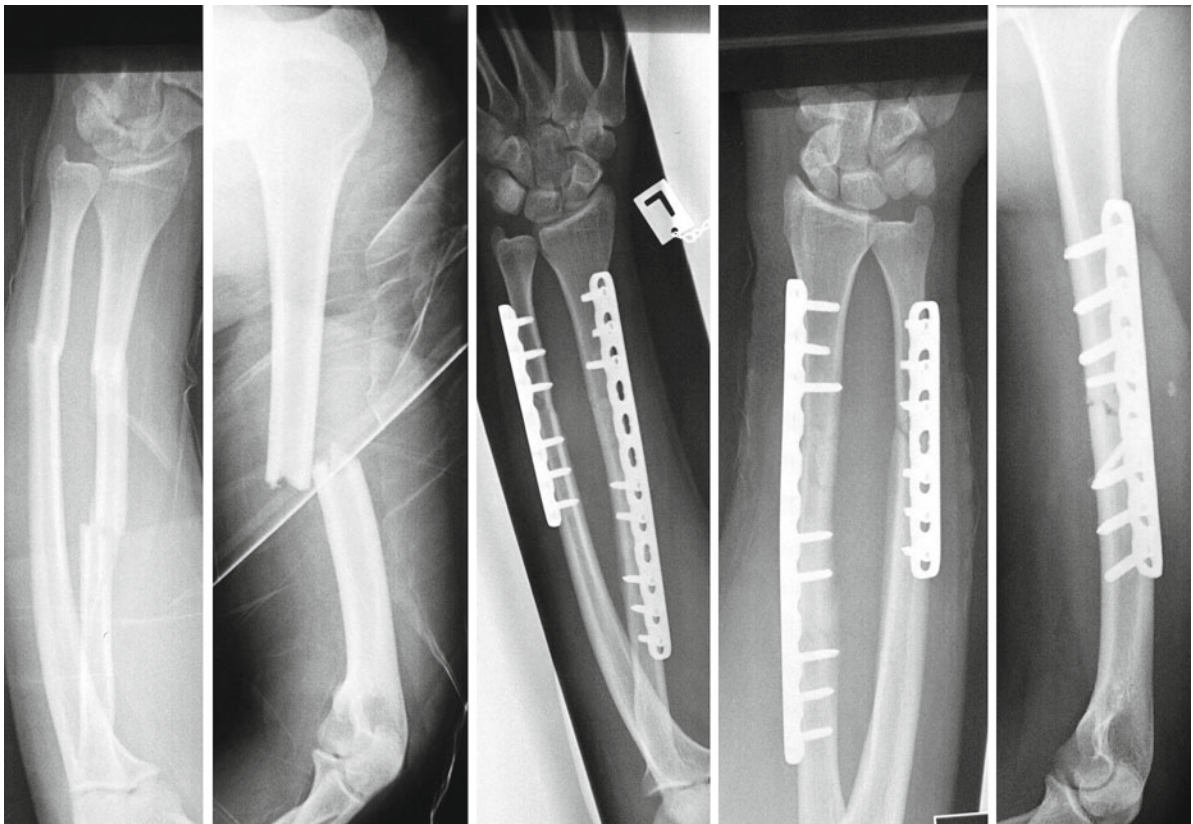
Serial fractures of the humerus, radius and ulna. Plate fixation of all fractured bones in one surgery. X-rays preoperatively and 6 weeks postoperatively
